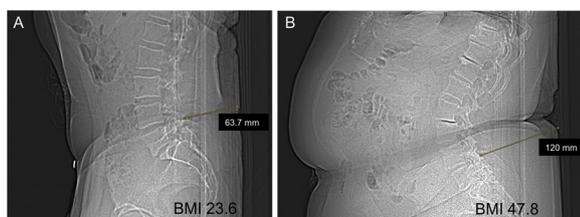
Localizer of preoperative computed tomograms with measurement of the distance from the skin to the facet joints at L4/5. In a normal-weight patient with a BMI of 23.6 kg/m² the distance was 64 mm (A). In a morbidly obese patient with a BMI of 47.8 kg/m² the distance was 120 mm (B).
